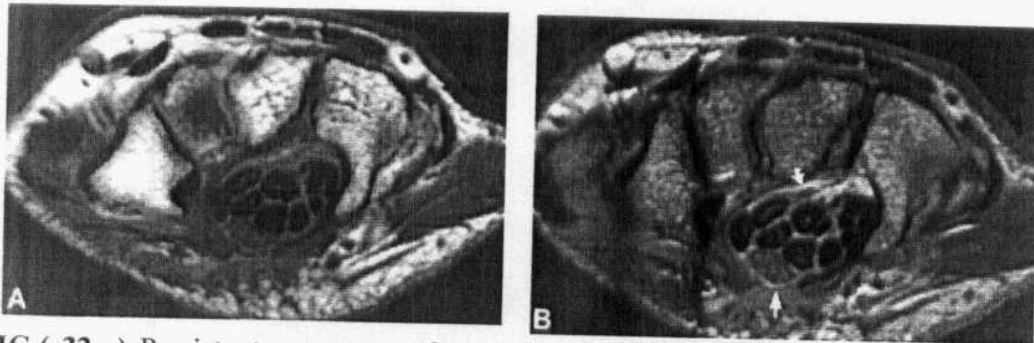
Persistent symptoms of carpal tunnel syndrome after endoscopic release of the flexor retinaculum. A thin band (straight arrow) is seen overlying the enlarged median nerve on T1-weighted (A) and intravenous gadolinium enhanced T1-weighted (B) axial images. These findings are consistent with an incomplete release of the flexor retinaculum. Enhancing synovitis is also shown deep to the profundus tendons (curved arrow) (Quoted from Stoller and Brody, 1997).
